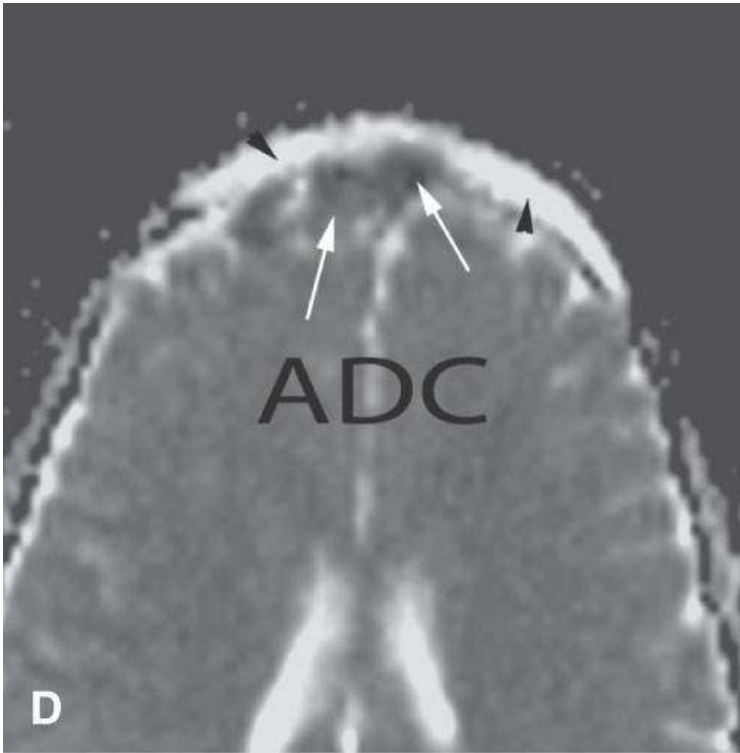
Magnetic resonance imaging of a patient with an epidural empyema and deep scalp abscess. A: T1-weighted contrast-enhanced image shows the epidural empyema (*arrow*) and scalp edema (*arrowheads*) with a small, likely subgaleal, abscess. B: T2-weighted image shows the two abscesses as in (A) (*arrow*) and related scalp edema (*arrowheads*). Diffusion-weighted image (C) and apparent diffusion coefficient (ADC) map (D) show restricted diffusion in the abscesses (*arrows*) but not in the scalp edema (*arrowheads*).
